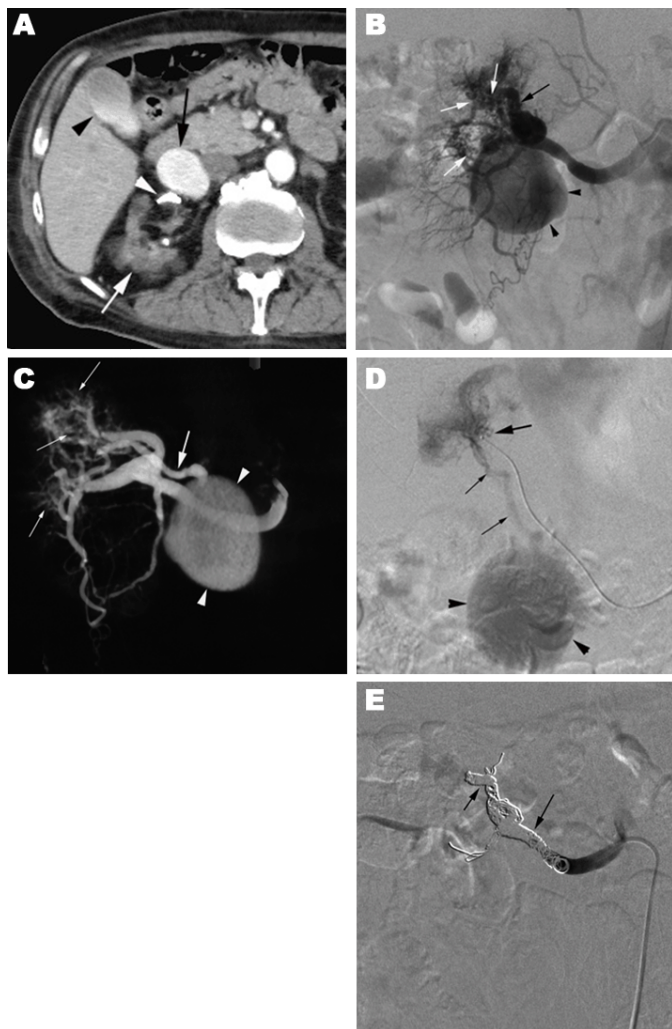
(A–E): (A) CT with intravenous contrast enhancement demonstrates a suggestive aneurysm (black arrow) in the right renal main trunk in the. Note the right end-stage kidney (white arrow) with acquired cysts, the excretion of the contrast material in the gallbladder (black arrowhead) and a calcification in the renal arterial branch (white arrowhead). (B) Right renal angiography shows fine and extensively distributed cirroid vessels (white arrows), a dilated segmental artery as the feeding artery (black arrow) and a large aneurysm (small arrowheads). Note: tortuous segmental arteries (large arrowhead). (C) Oblique cone beam CT image of a right renal angiography shows the aneurysm (arrow heads) is connected to a draining vein (large arrow) of the cirroid AVM (small arrows). (D) Right renal interlobar angiography shows cirroid vessels (large arrow) and draining vein (small arrows) which is connected to the venous aneurysm (arrowheads). (E) Post-embolization right renal angiography shows complete occlusions of right renal main trunk artery and the segmental artery with multiple detachable coils (arrows) and no visualization of intrarenal arterial branches and the aneurysm.
